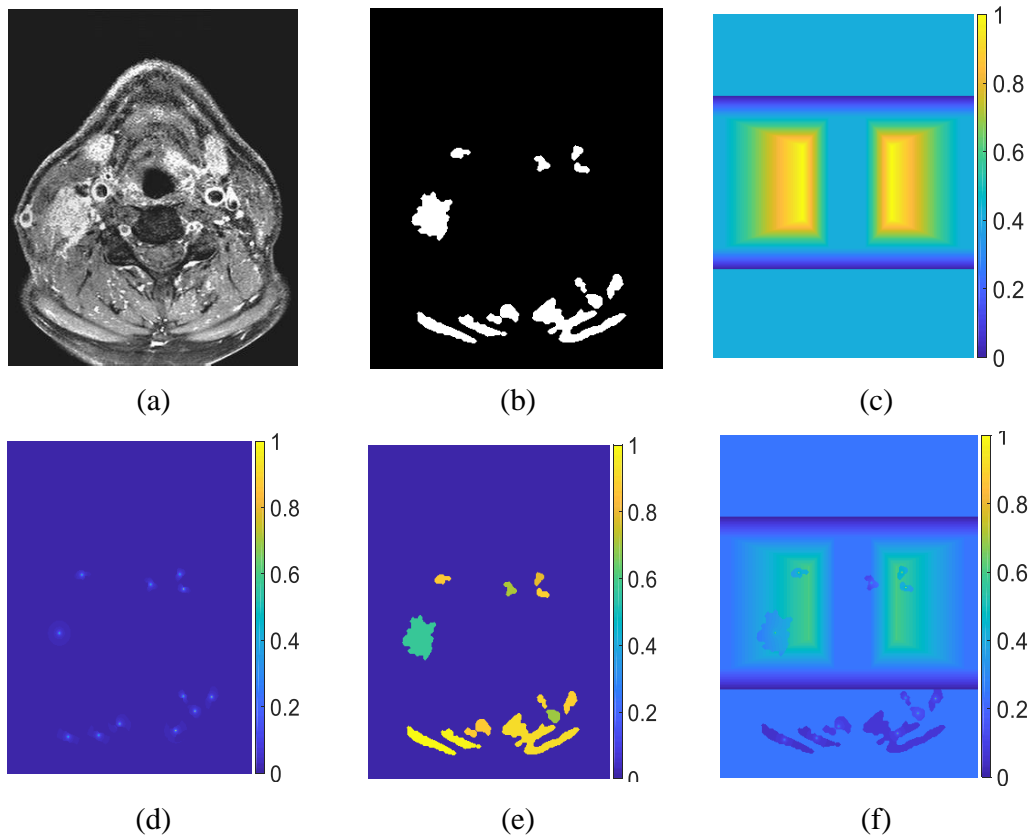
Construction of Probability map. (a) Input MRI slice (MR28082014) (b) Rough ROIs on  $I_B$  (c) Probability map distribution deduced from  $W_{location}$  (d) Probability map distribution deduced from  $W_{location}$  (e) Probability map distribution deduced from  $W_{size}$  (f) Probability map distribution deduced from  $W_{eccentricity}$  (f) Final probability map combines all factors. The colour bar on right side of each map represents the probability values.
